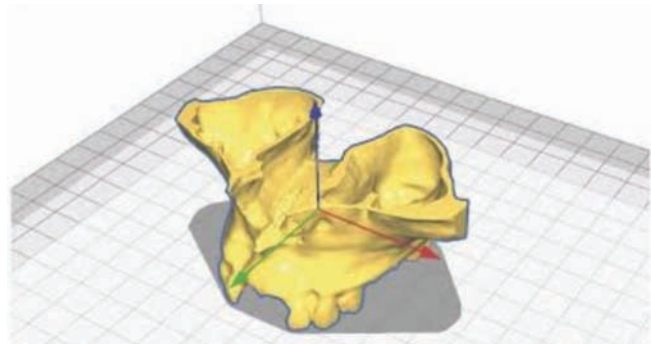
A 3D object (reconstructed model of a maxillary CBCT scan) is positioned in the 3D space of a software (Ultimaker Cura) to be 3D printed. Note the three axes depicted by the software in different colors (x-axis in red, y-axis in green, z-axis in blue).
